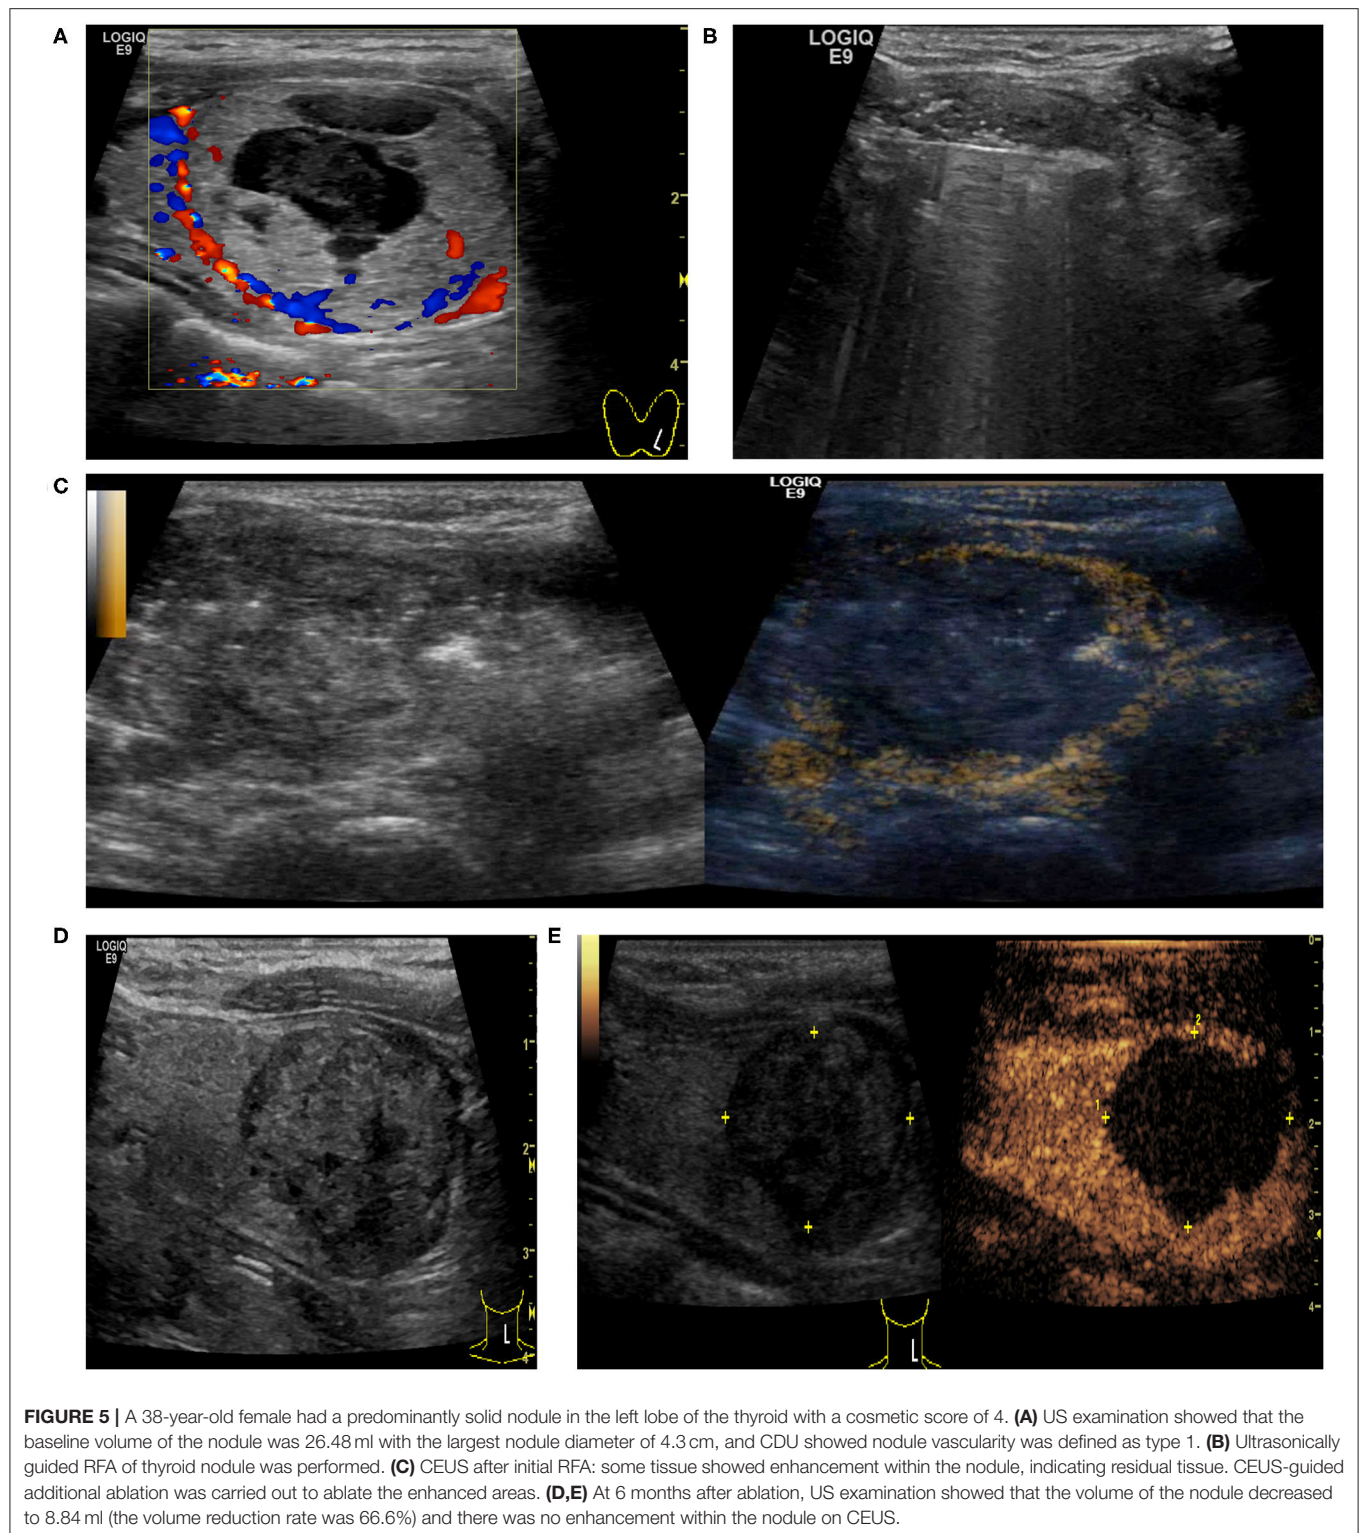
A 38-year-old female had a predominantly solid nodule in the left lobe of the thyroid with a cosmetic score of 4. (A) US examination showed that the baseline volume of the nodule was 26.48 ml with the largest nodule diameter of 4.3 cm, and CDU showed nodule vascularity was defined as type 1. (B) Ultrasonically guided RFA of thyroid nodule was performed. (C) CEUS after initial RFA: some tissue showed enhancement within the nodule, indicating residual tissue. CEUS-guided additional ablation was carried out to ablate the enhanced areas. (D,E) At 6 months after ablation, US examination showed that the volume of the nodule decreased to 8.84 ml (the volume reduction rate was 66.6%) and there was no enhancement within the nodule on CEUS.
